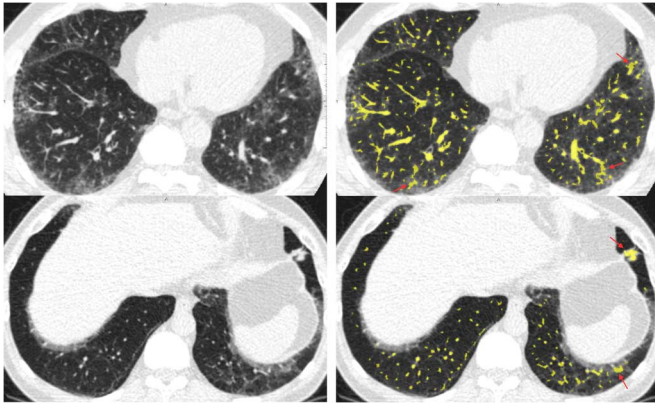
Examples of some errors in the vessel segmentation in two different cases, where the first frame of each row shows an axial slice of the original CT scan and the second frame shows the vessel segmentation as an overlay on the original scan. The red arrows in the second frame indicate some examples of non-vascular parts in the vessel segmentation.
